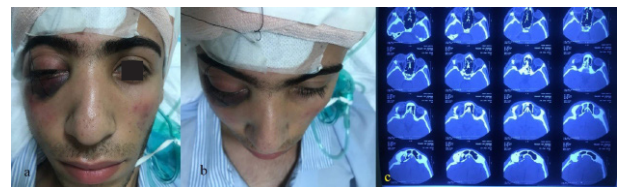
A,B) proptosis is one of clinical manifestation of retrobulbar hemorrhage. C) retrobulbar blood accumulation is seen in post-operative orbital CT scan.
